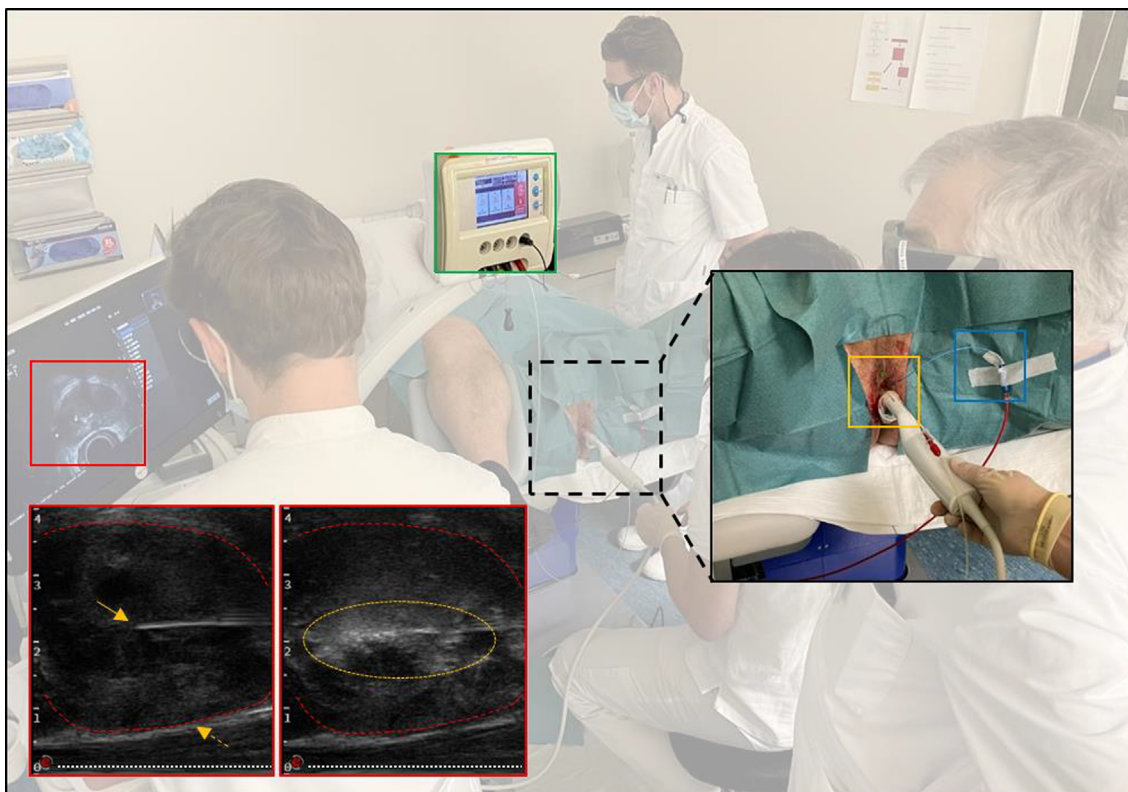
Perioperative overview of a transperineal focal laser ablation (TPLA) for prostate cancer treatment at the outpatient clinic. TPLA was performed by two urologists—one ultrasound operator and one person monitoring vital functions. Free-hand continuous transrectal ultrasound guidance (middle red box) and needle guide allow for accurate placement of periprostatic block, laser fiber (yellow box), and thermosensor at the rectal wall (blue box). Longitudinal grayscale ultrasound image (lower left red box) displaying laser fiber (arrow), thermosensor (dotted white line), and prostatic tissue (dotted red lines) before laser diode activation (green box). Hyperechogenic prostatic tissue and gaseous bubble formation (dotted ellipse) surrounding laser fiber because of laser-tissue interaction (lower right red box).
